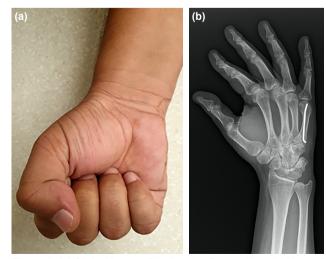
(a) Clinical image of the hand at flex position. (b) X-ray of the case with K wire migration.
